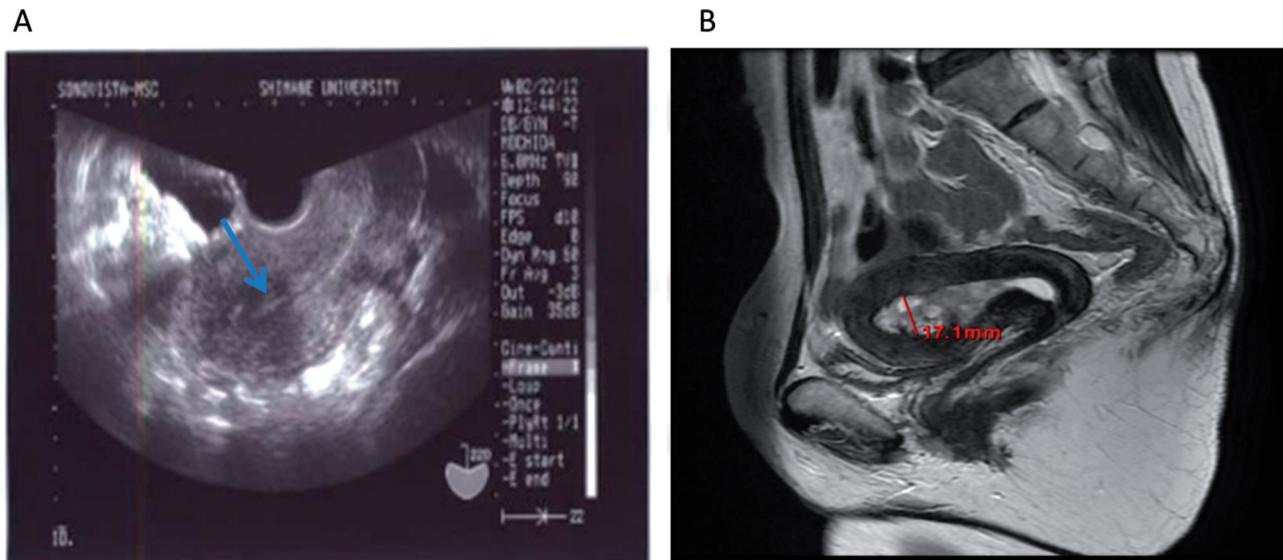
(A) Ultrasound reveals a thin endometrium (2 mm) three months after MEA. (B) MRI reveals a thickened endometrium (17 mm) five years after MEA.
